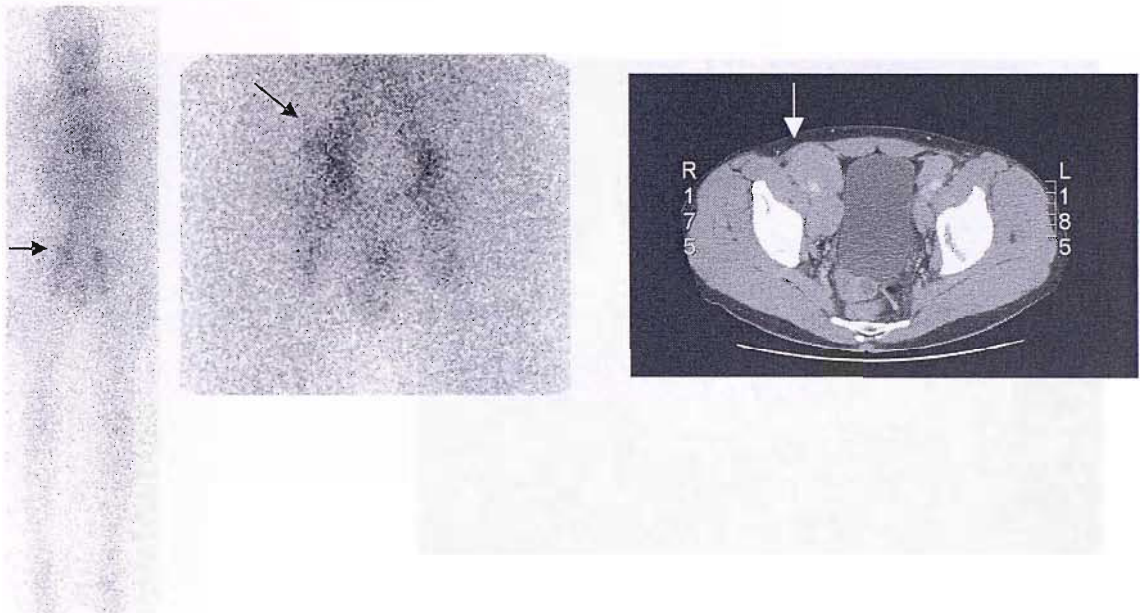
A) Gamma camera images of patient RH taken prior to the first fraction of RIT indicating targeting of ^{131}I rituximab to the pelvis (arrows) correlating with the site of bulky pathologically enlarged lymph nodes demonstrated on the pre treatment CT. B) Gamma camera images of patient RH prior to second fraction of RIT showing some reduction in intensity of uptake in the pelvis. This appears to correlate with clinical response and partial resolution of the palpable right iliac fossa mass confirmed on CT scan performed at week 25.
